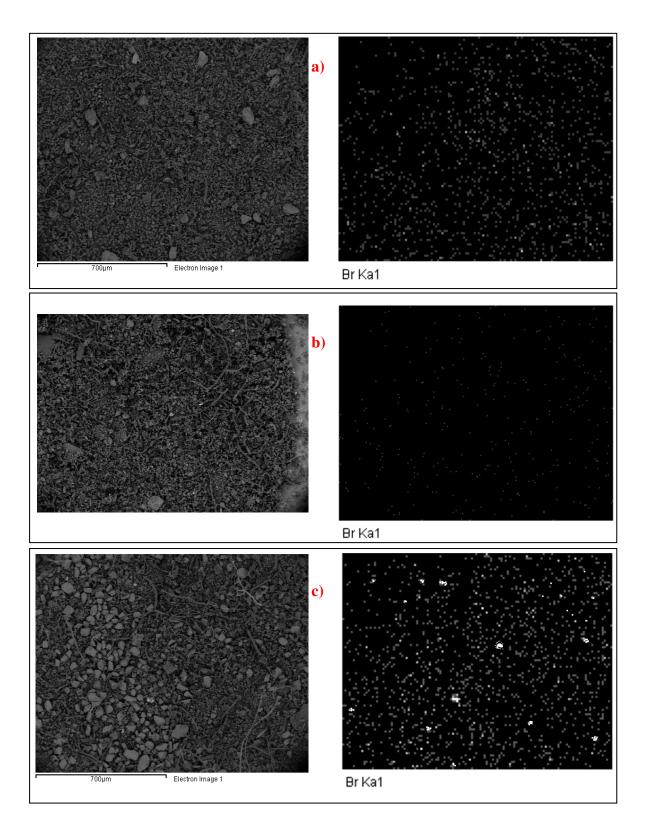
x-ray EDS mapping of (a) sample 1 showing homogenous distribution of bromine (b) sample 5 showing homogenous but very low bromine content (c) sample 4 showing localised bright patches rich in bromine.
